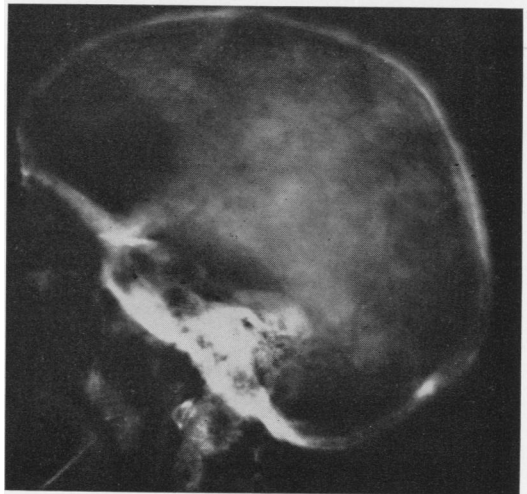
Case 4. X-rays interpreted as Paget's disease of humerus and skull, later revised to osteitis fibrosa cystica.
